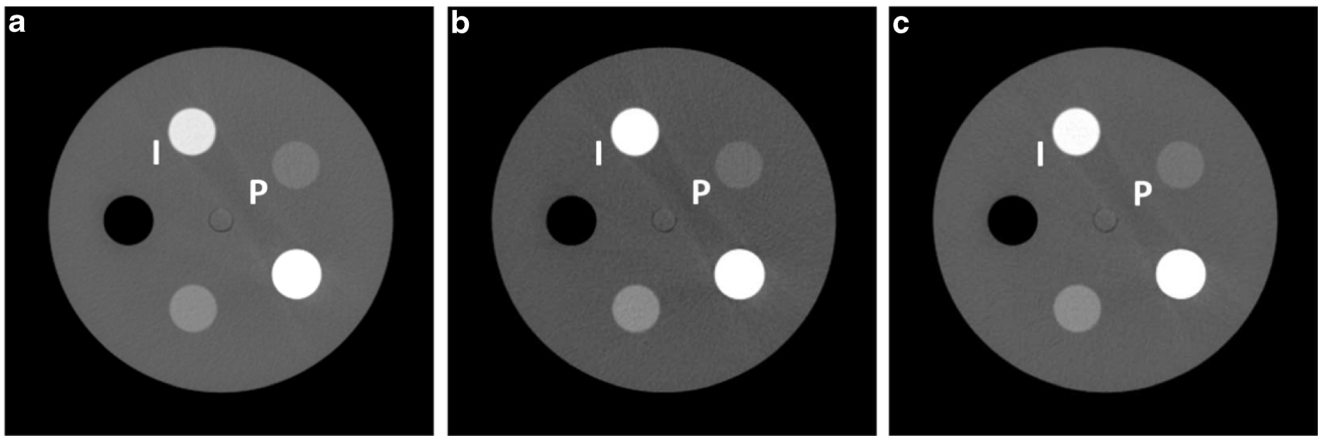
Axial CT images of the 18.5 cm module demonstrating the impact on iodine (I) and soft tissue (P) inserts scanned (a) with standard protocol without ATPS (120 kVp), (b) with ATPS in CTA mode (80 kVp chosen by ATPS), and (c) with ATPS in non-contrast mode (100 kVp chosen by
